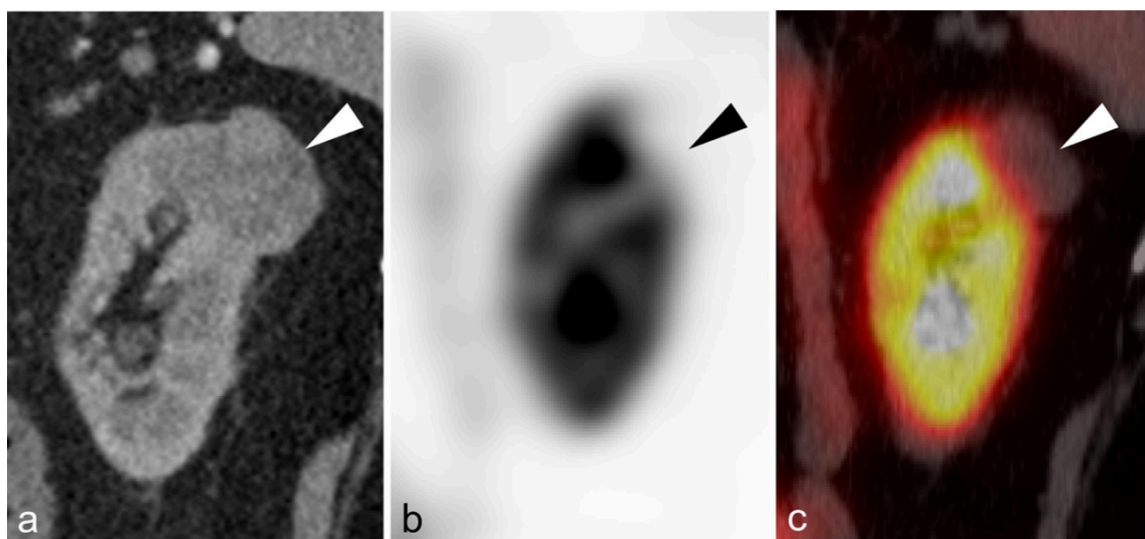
(a) Sagittal arterial/corticomedullary phase contrast-enhanced CT, (b) sagittal ^{99m}Tc -sestamibi SPECT, and (c) sagittal ^{99m}Tc -sestamibi SPECT/CT fusion images of a predominantly exophytic photopenic (i.e., “cold”) tumour (white and black arrowheads) with uptake markedly less than the adjacent normal renal parenchyma. This lesion was resected and was found to be a clear cell RCC.
